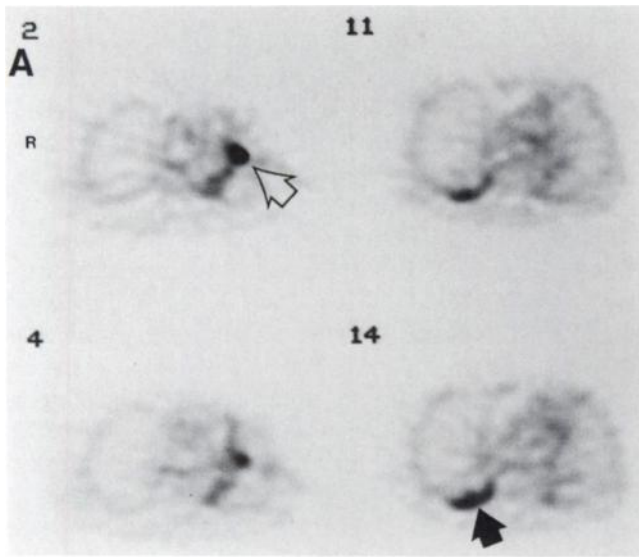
Patient 13, a 62-yr-old man with an adenocarcinoma. (A) FDG-PET image shows focal uptake (open arrow) in the hilar area of the left lung and curvilinear-shaped uptake (arrow) in the posterior base of the right lung. (The lower number indicates the higher slice level of the lung.) (B) CT demonstrates a possible nodule (open arrow) in the left hilar area and possible inflammatory changes (arrow) in the right posterior lung field. The right pleural effusion increased over the next few weeks, but the cultures and cytology were negative. Bronchoscopy of the left bronchus was suggestive of submucosal tumor invasion.
